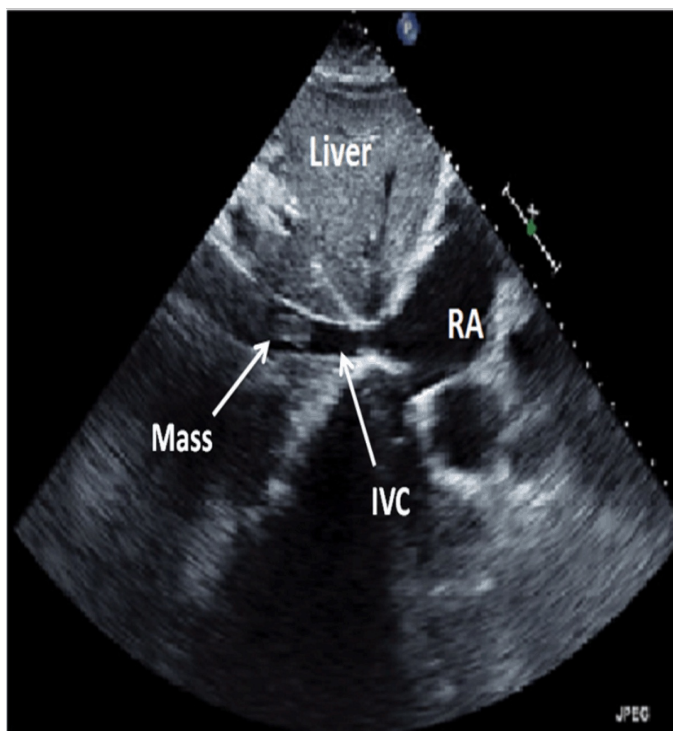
Two-dimensional echocardiogram showing a mass in the IVC two cm below the right atrium.
